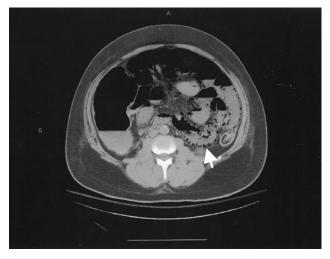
Computed tomography scan demonstrating extensive pneumatosis intestinalis (*arrow*).
